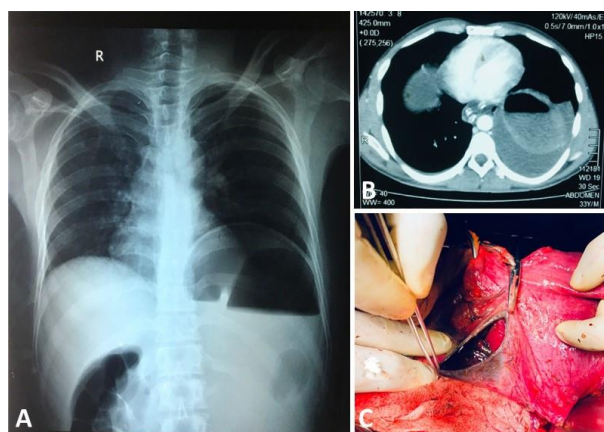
A, Chest x-ray showing left hemi-diaphragmatic elevation with pneumoperitoneum; B, Computed tomography scan showing protrusion of abdominal contents into left thoracic cavity; C, Intra-operative photo depicting gastric perforation at the fundus.
